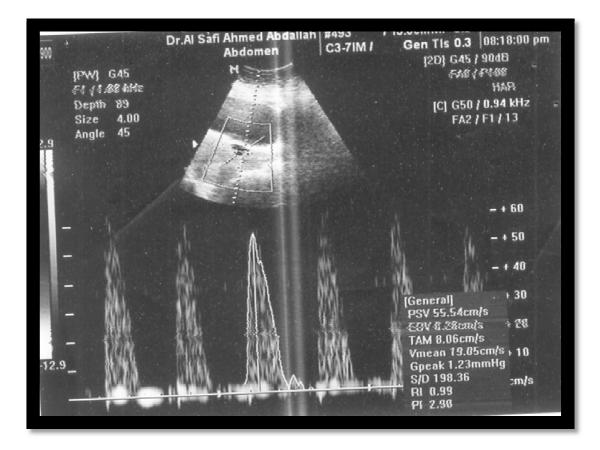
Trans- abdominal color Doppler scan for a 35 old women has a history of (RPL) Showing complete abortion.
